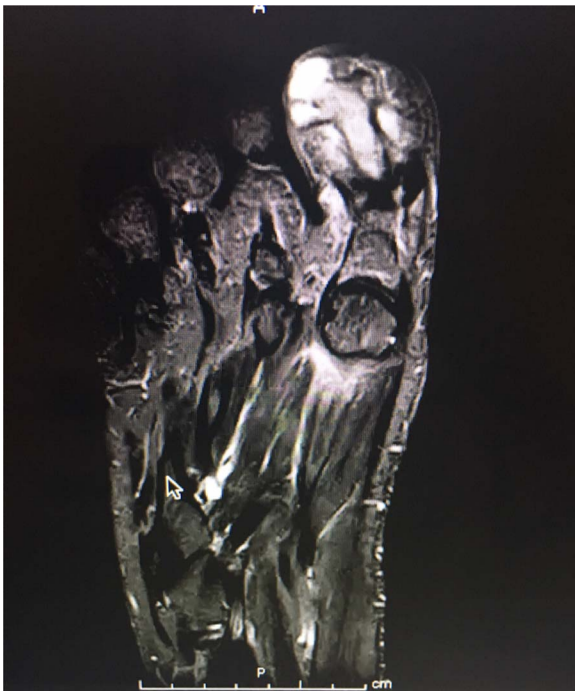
MRI of Right foot with and without contrast: There is abnormal marrow signal intensity throughout the distal phalanx of the great toe. This is T1 hypointense with enhancement and STIR hyperintense. Findings compatible with acute osteomyelitis.
